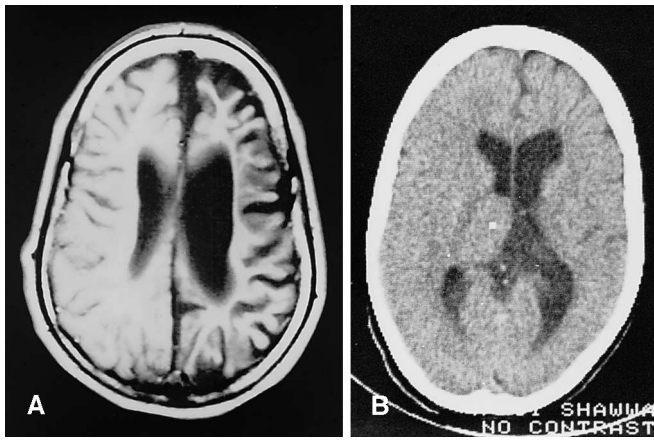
A Global left-sided cerebral hemiatrophy on T1-weighted MRI image in case 2. B Cranial CT in case 4, showing atrophy of the right hemisphere and dilatation of the right ventricle. Note the associated atrophy of the right caudate nucleus and thalamus
